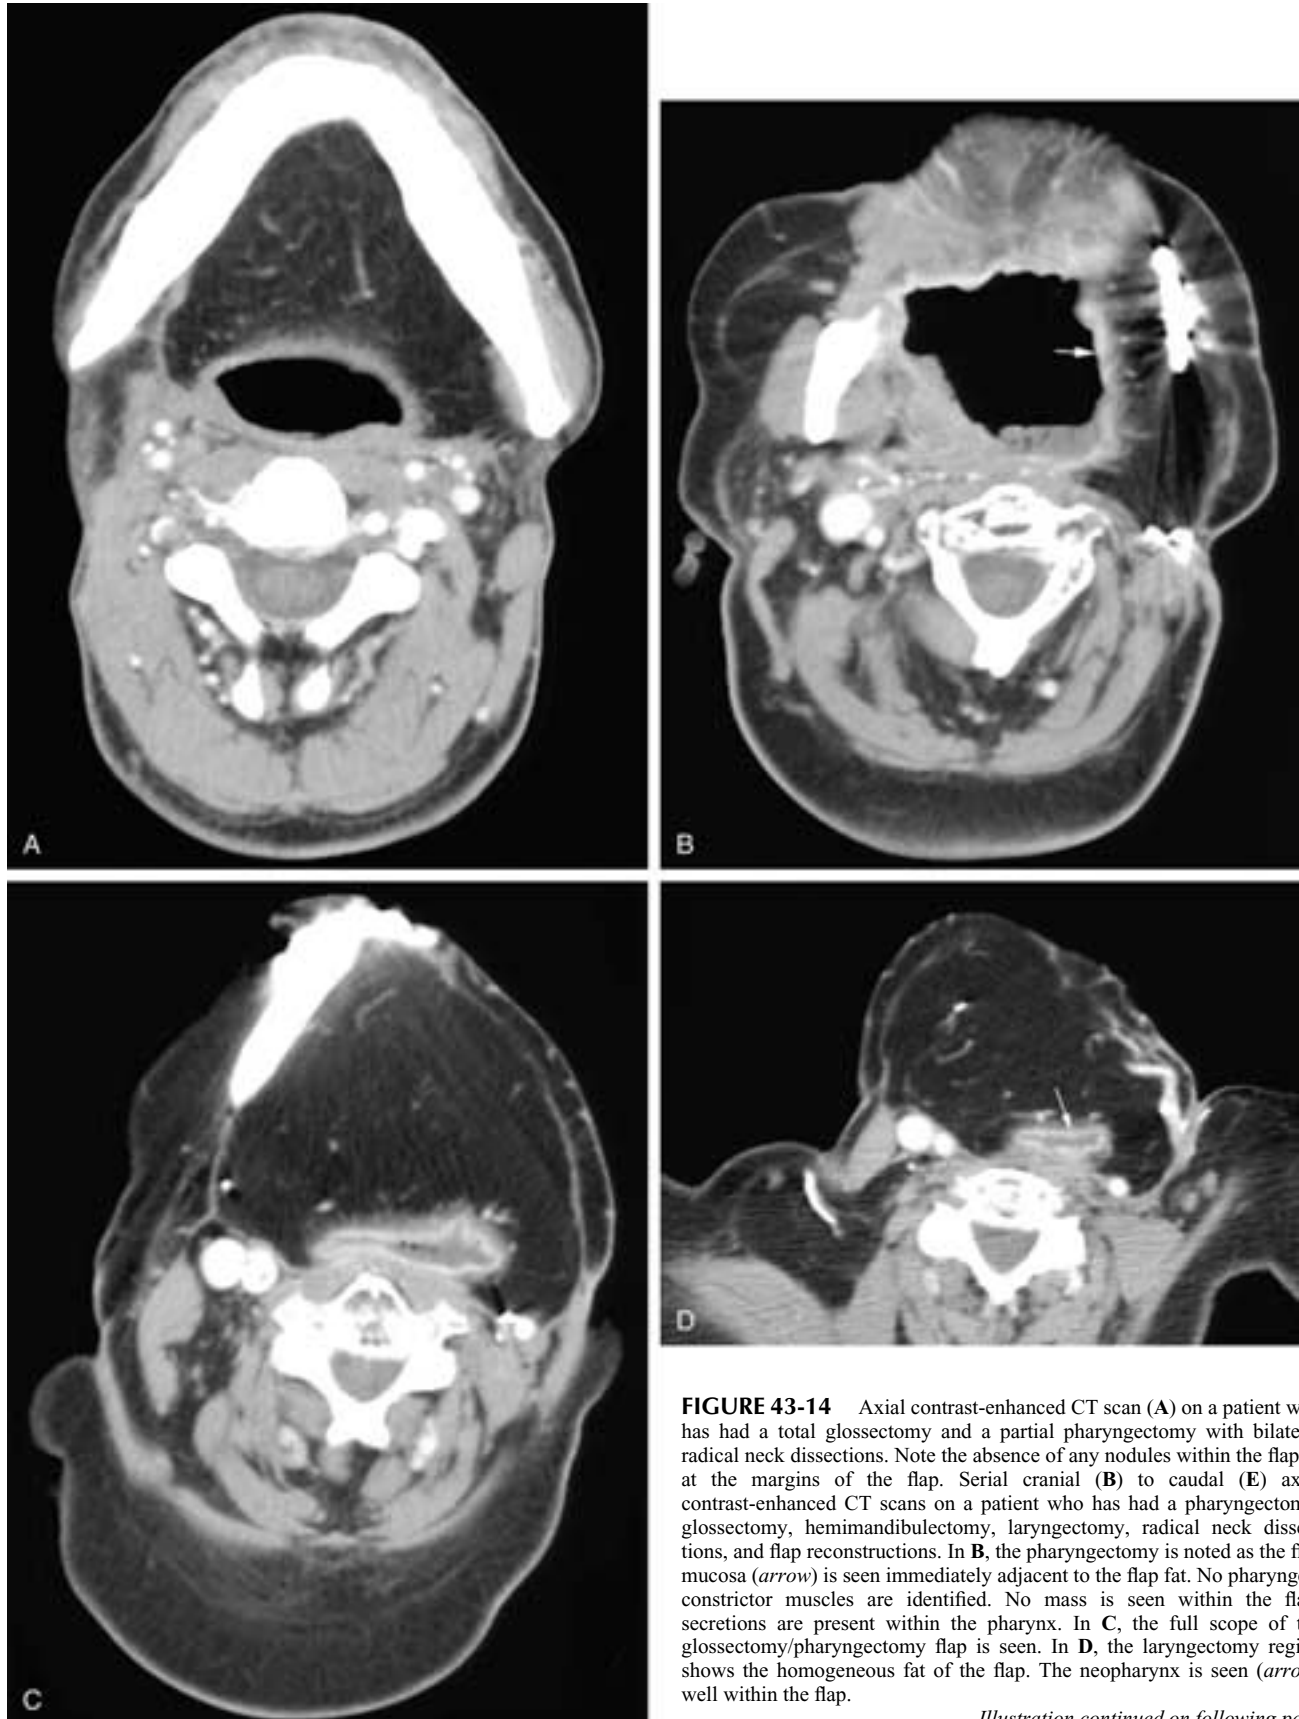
Axial contrast-enhanced CT scan (A) on a patient who has had a total glossectomy and a partial pharyngectomy with bilateral radical neck dissections. Note the absence of any nodules within the flap or at the margins of the flap. Serial cranial (B) to caudal (E) axial contrast-enhanced CT scans on a patient who has had a pharyngectomy, glossectomy, hemimandibulectomy, laryngectomy, radical neck dissections, and flap reconstructions. In B, the pharyngectomy is noted as the flap mucosa (arrow) is seen immediately adjacent to the flap fat. No pharyngeal constrictor muscles are identified. No mass is seen within the flap; secretions are present within the pharynx. In C, the full scope of the glossectomy/pharyngectomy flap is seen. In D, the laryngectomy region shows the homogeneous fat of the flap. The neopharynx is seen (arrow) well within the flap.
